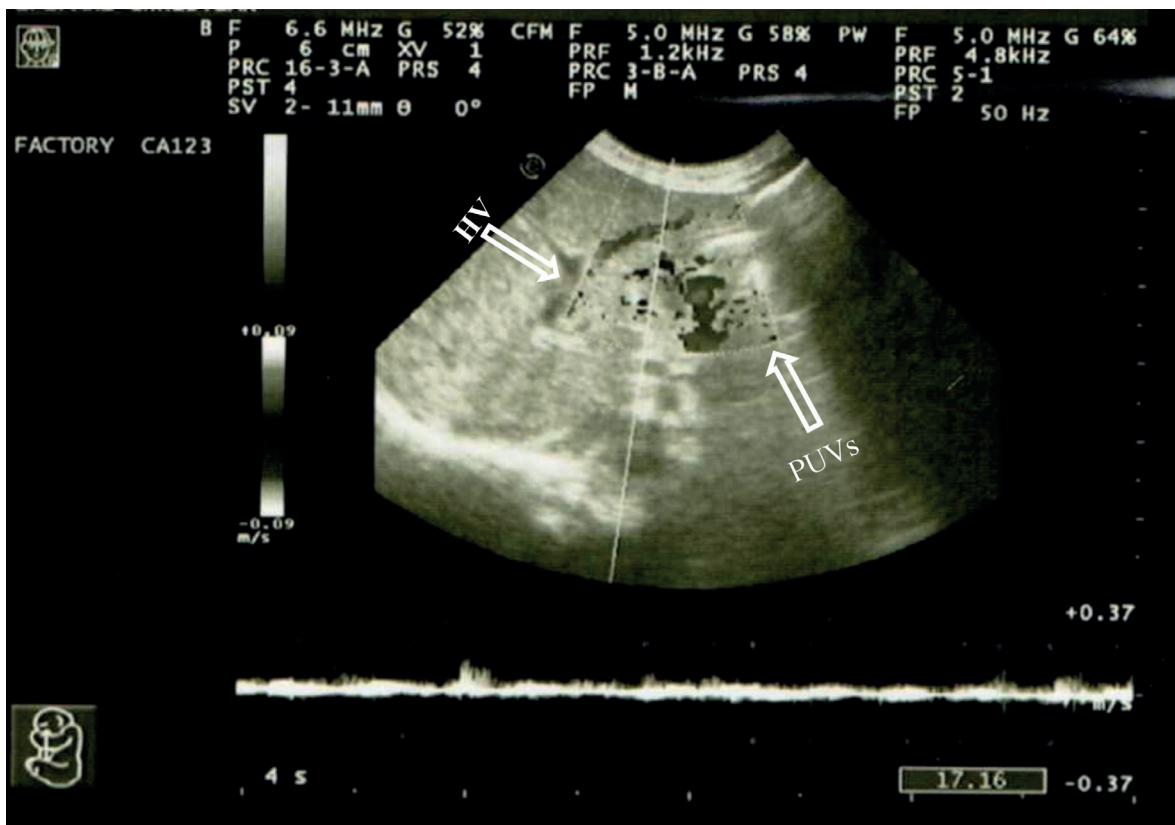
Postnatal Doppler ultrasonography examination showing paraumbilical veins (PUVs) and hepatic vein (HV).
